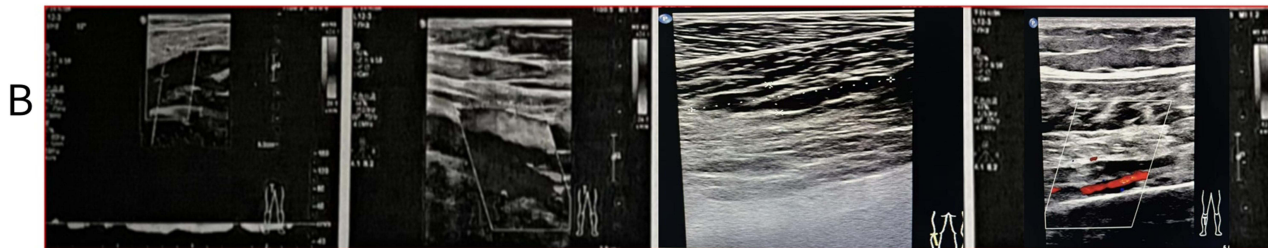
Venous ultrasound images showed thrombus formation in the intermuscular veins in the left calf (A) and the peroneal vein and the partial muscle vein in the right calf (B) of a representative patient in the Non-device group 3 days after surgery. The main vein of the left (A) and right (B) lower limb was displayed, and there was no obvious abnormality in its course. A slightly dilated vein can be seen between the left calf muscles, with a low echo pattern inside. The range was approximately 18.7 mm x 2.3 mm (A), and the peroneal vein and some of the intermuscular veins of the calf are slightly dilated, filled with low echoes with a width of 4.2 mm (B). (A and B) The lumen deformation of the probe compression was not obvious, and no obvious blood flow signal was seen inside. There was no clear solid echo in the lumen of the main vein of the remaining left and right lower limb, and the lumen can be closed when the probe is pressurized. CDFI + PWV: The blood flow signal inside is well-filled; there is no obvious abnormality in the direction and speed of blood flow in a calm state. No thrombi were found in the deep and superficial veins in the left and right thigh. Abbreviations: CDFI, Color Doppler flow imaging; PW, Pulsed-wave Doppler ultrasound.
